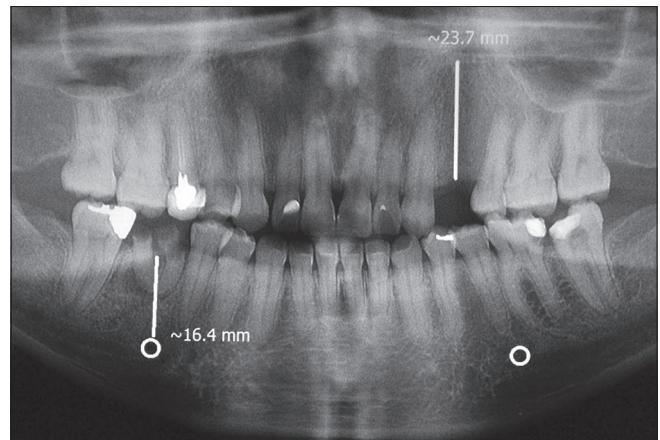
Antemortem panoramic radiograph of the victim dating from 2013
